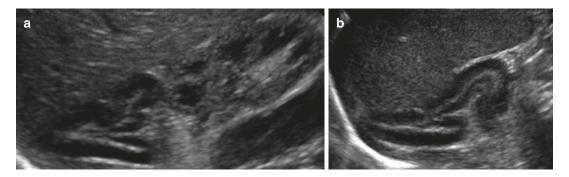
Normal adrenals. Ultrasound appearance of (a) right and (b) left adrenal glands. Note the layering appearance due to the thick hypoechoic cortex and echogenic central medullary portion
